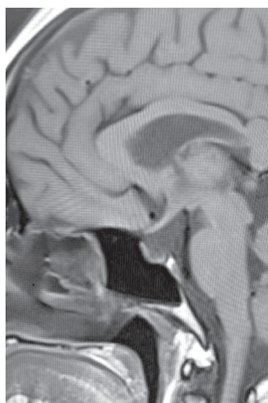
MRI brain T1-weighted sagittal image showing empty sella.
